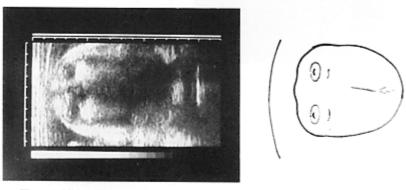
Ultrasound scan demonstrating both orbital cavities containing the lens
